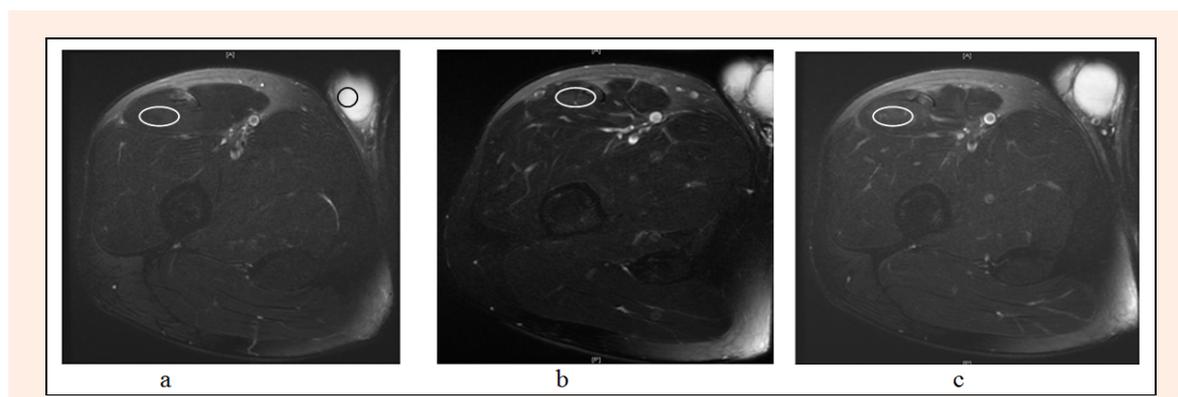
Sample of MRI images from one of the participants in this study. The region of interest (oval white circle) is placed in the rectus femoris muscle where T2 intensity was measured for pretest (a), after NM (b) and ER (c) trainings. The control measurement was taken from the centre of the adjacent testicle (black oval circle) as shown in Figure 1a. The ratio of the measurements forms a constant value allowing variation in display parameters.
